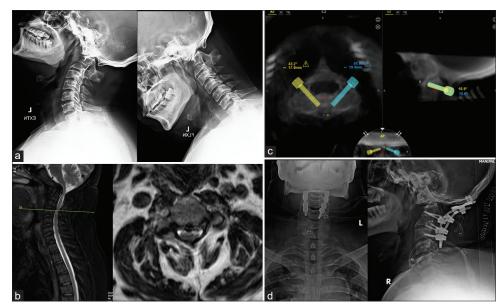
Preoperative radiographs (a) and magnetic resonance imaging (b) of a patient with basilar invagination. Screenshot of C2 pedicle screw planning (c) and post-operative radiographs following occipito-cervical fusion (d)
